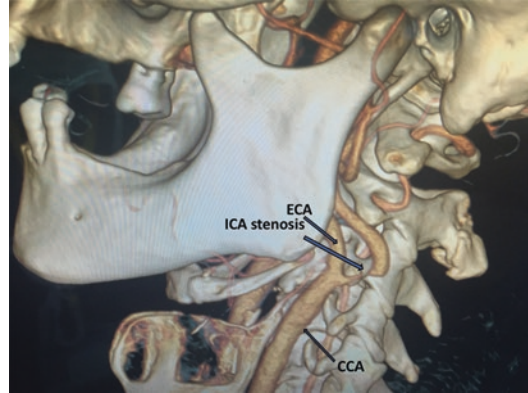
3D reconstruction image of preocclusive carotid stenosis of internal carotid artery on CT angiographic examination (CCA common carotid artery, ICA internal carotid artery, ECA external carotid artery)
